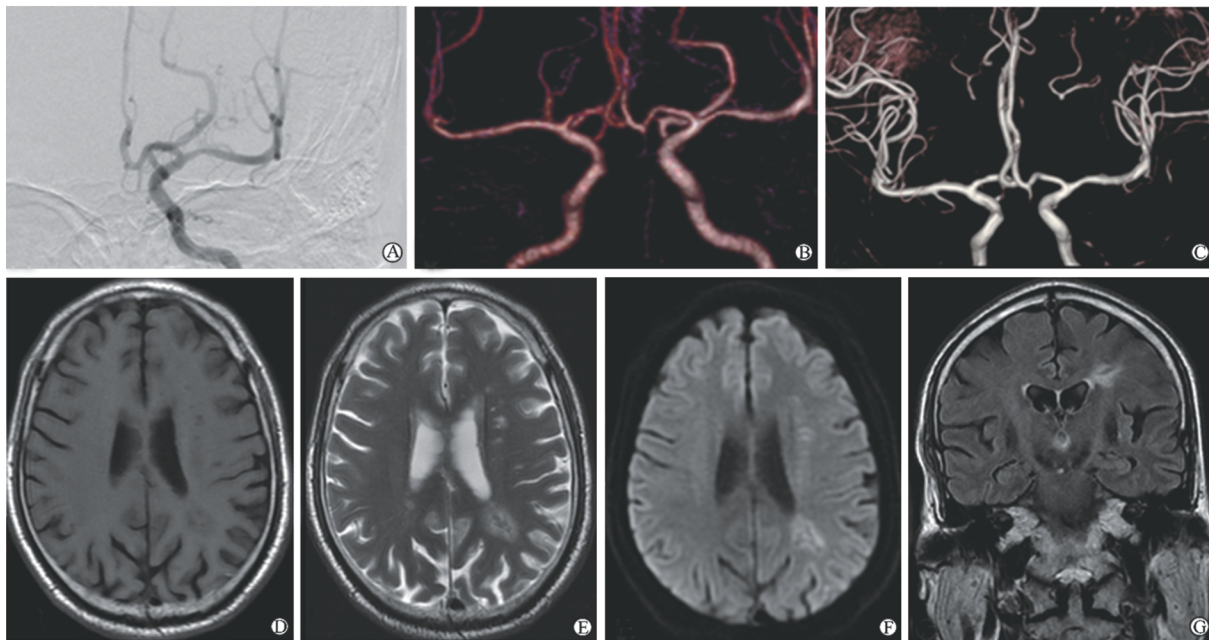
左侧大脑中动脉轻度狭窄患者 DSA (A)、CTA (B)、TOF-MRA (C)及 MRI 常规图像 (D-G)
